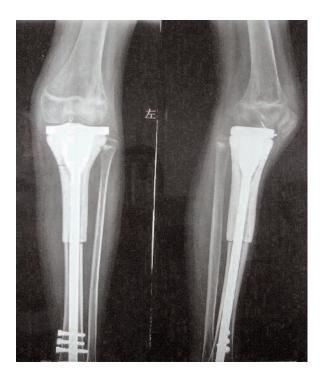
X-ray examination after operation.
